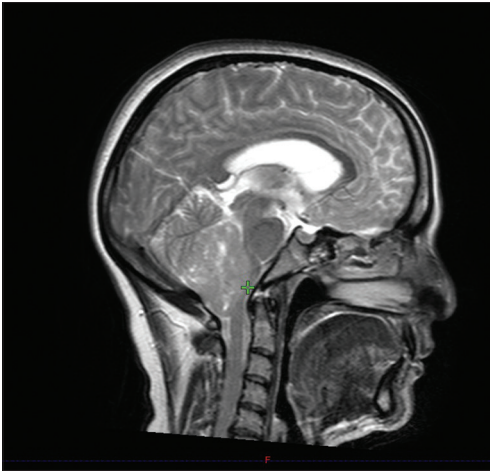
Sagittal magnetic resonance imaging image showing the craniocaudal extent of the tumor up to the cervicomedullary region
